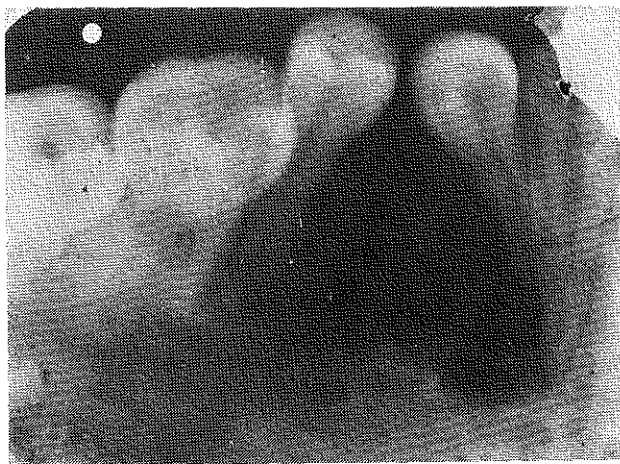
A radiograph of the right side of the mandible of 29-year-old woman. An unilocular radiolucency was present in the bone between the premolar teeth.
